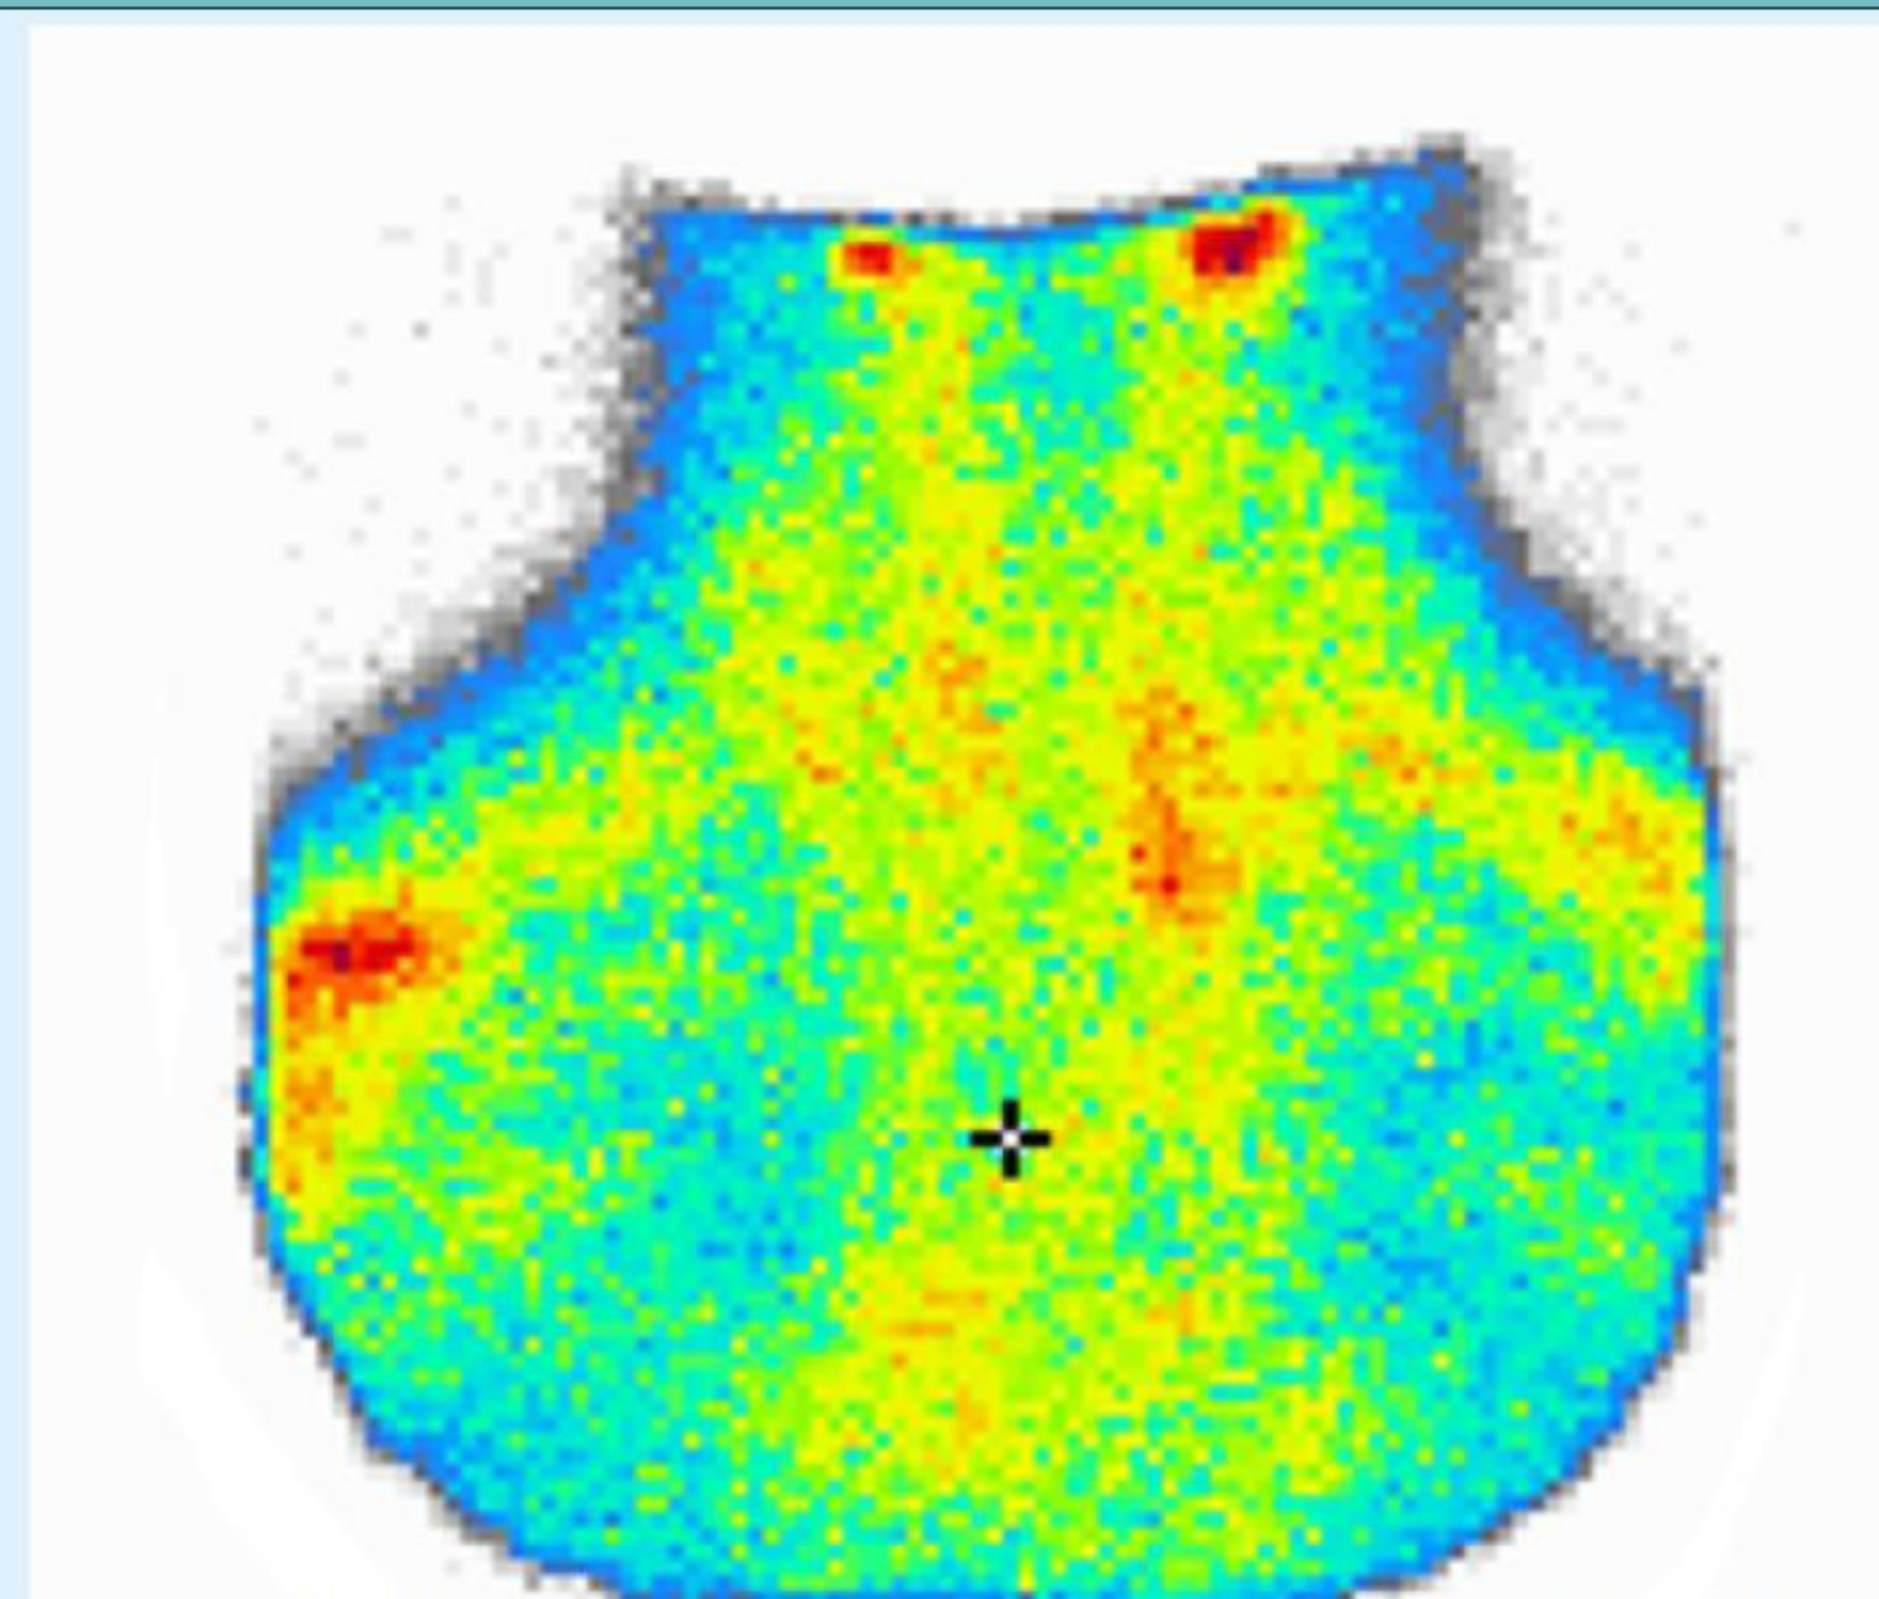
Parathyroid adenoma. Sestamibi scintigraphy of the neck.
